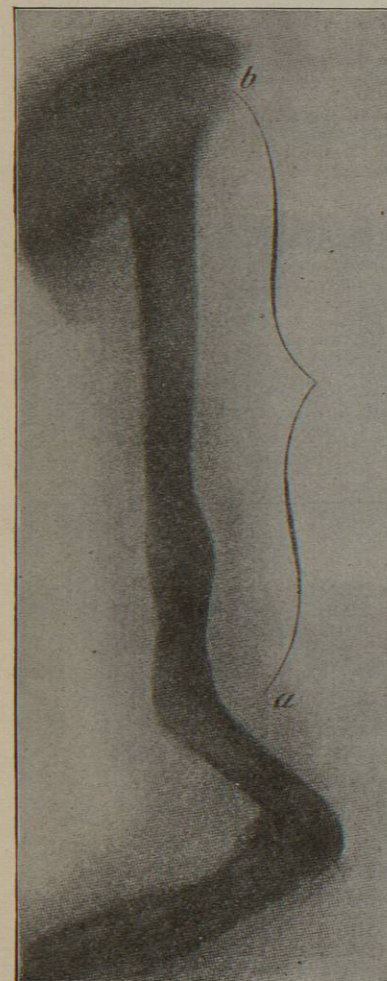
Radiograph of Arm, Showing Successful Transplantation of Piece from Tibia to Take Place of Humerus. a-b, The portion of bone transplanted. (Klapp.)
